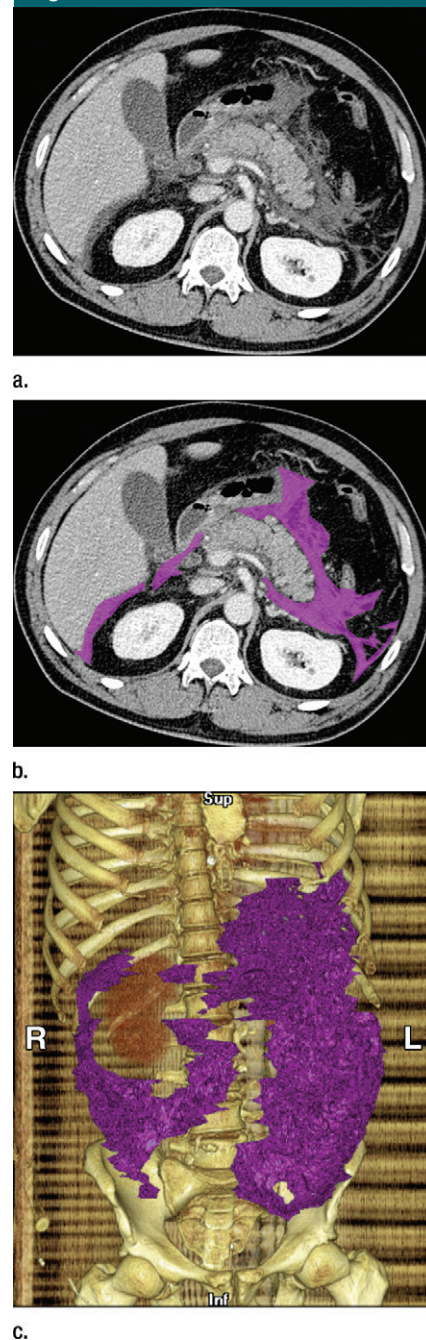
Images show acute pancreatitis graded as mild by using the CTSI (score = 4 for two or more fluid collections) with 1326 mL (>100 mL) of extrapancreatic necrosis in a patient with severe organ failure at follow-up. (a, b) Axial reconstructions from a CT study show segmentation of extrapancreatic necrosis in purple. (c) Three-dimensional model produced from segmentation of extrapancreatic necrosis.
